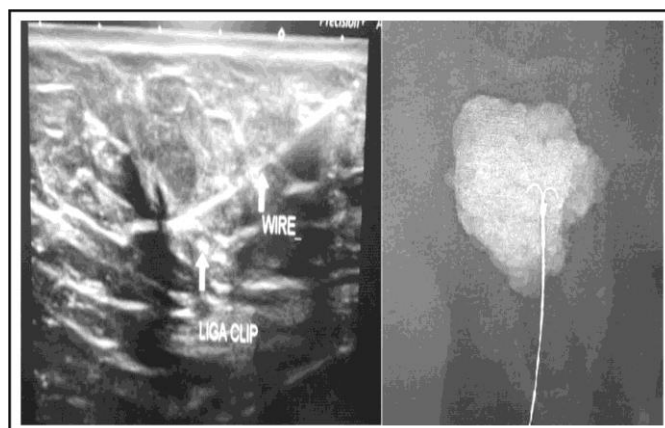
Ultrasound guided wire localization of residual lesion with liga clip. 1B: Successful retrieval of tumor bed contain clip and wire in place.
